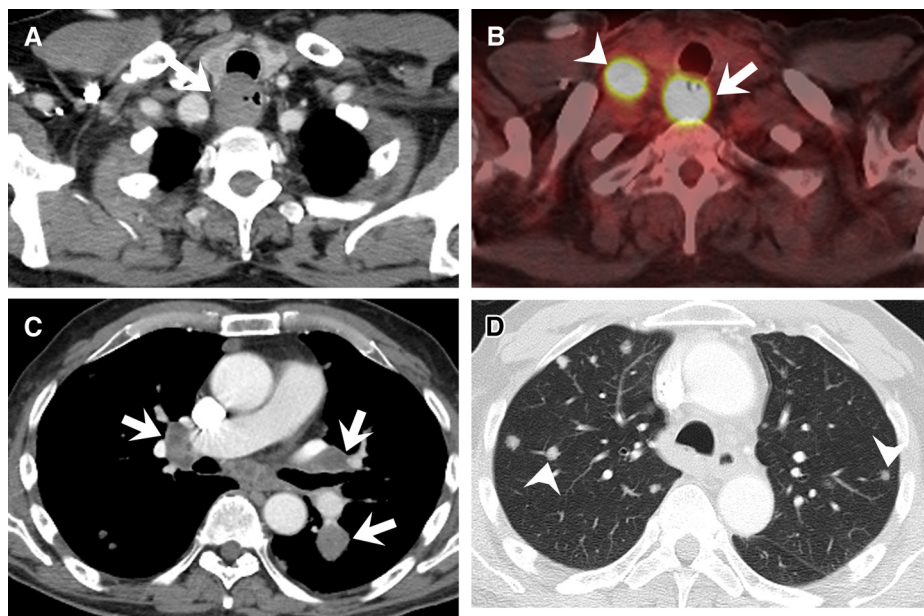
A 60-year-old woman with cervical esophageal cancer. (A) Axial contrast-enhanced computed tomography (CT) image of the chest reveals an intraluminal polypoid mass in the esophageal lumen (arrow). (B) Axial fused fluorodeoxyglucose (FDG) positron emission tomography/CT image demonstrates intense FDG uptake in the esophageal mass (arrow) and a concurrent FDG-avid right supraclavicular node (arrowhead). Endoscopic biopsy of the mass confirmed squamous cell carcinoma. Patient was treated with chemoradiotherapy. (C, D) Axial CT images of the chest 12 months after the treatment demonstrate extensive metastatic bilateral hilar lymphadenopathy (arrows) and metastatic pulmonary nodules (arrowheads).
